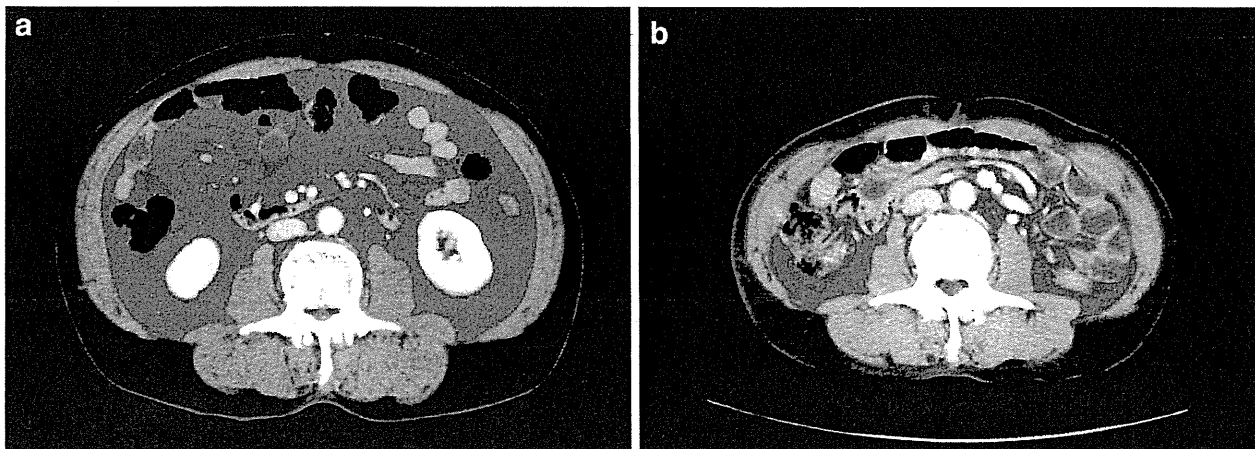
Typical transverse CT images at L3 show postoperative changes in visceral adipose tissue (green). The preoperative visceral adipose tissue area of 161 cm² (a) decreased to 16 cm² at 1 year after surgery (b)
